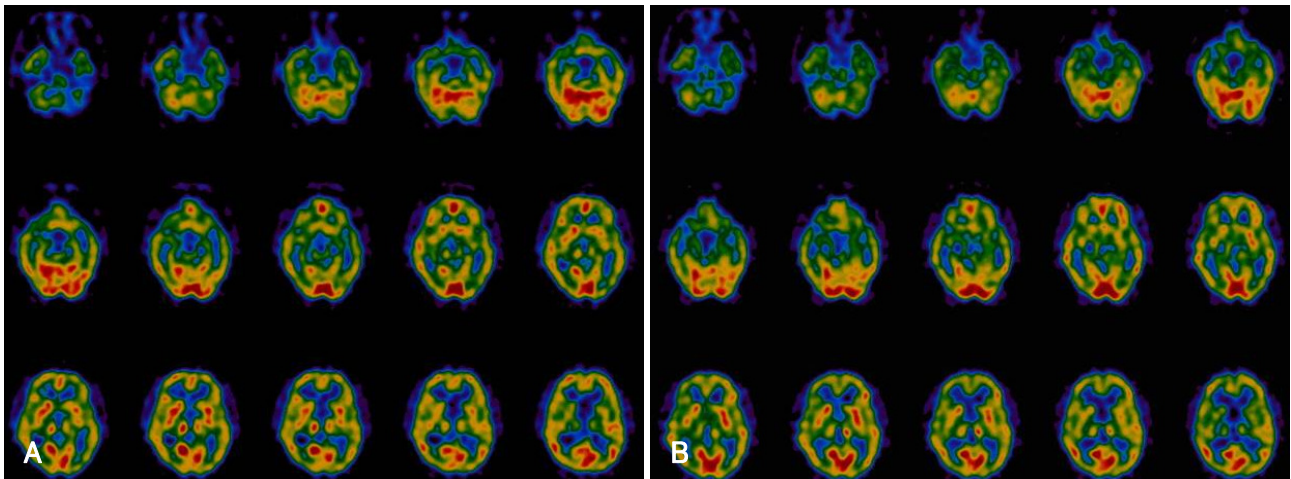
A: single-photon emission CT scanning with a ^{99m}Tc -ethyl cysteinate dimer revealed decreased uptake in the right cerebral hemisphere. B: scans obtained after the Diamox challenge showed no increase in cerebral flow in the right cerebral hemisphere, suggestive of a decrease in vascular reserve.
